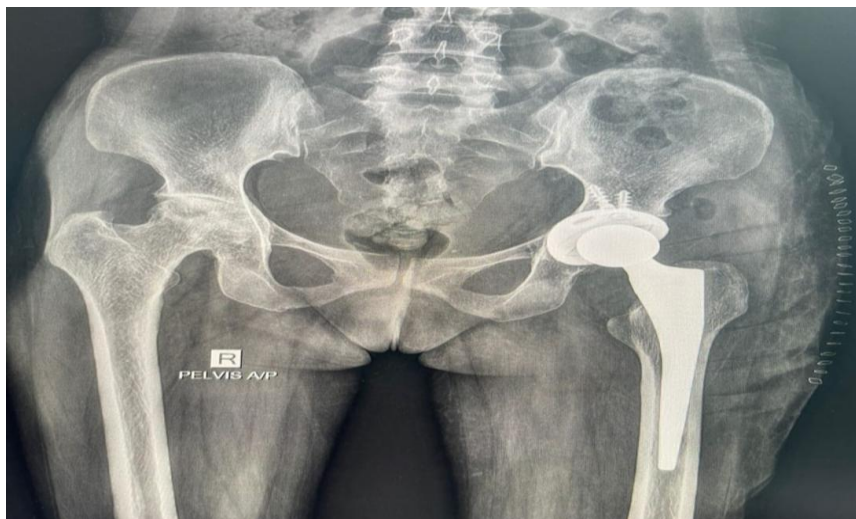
X-ray of Pelvis and both Hip Joints (AP View) with Right Total Hip Replacement (Pre-Operative)
